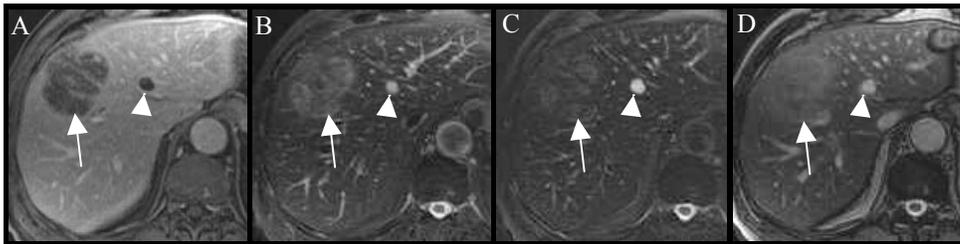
T1 axial-enhanced (A), moderate T2-weighted (B; TE 80), heavily T2-weighted (C; TE 160), and FIESTA (D) sequences demonstrate a large hepatic metastasis (arrows) and small cyst (arrowheads). Note that on both the heavily T2-weighted and FIESTA sequences, malignant lesions are similarly poorly defined and only mildly increased in signal compared to adjacent hepatic parenchyma, while benign lesions are well-defined and of relative increased signal intensity.
